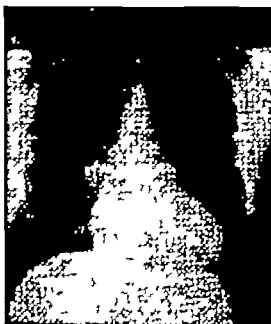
Posteroanterior roentgenogram. A 29 year old white male with ventricular septal defect. Note the increased pulmonary vascular markings. The pulmonary conus seems less prominent than is usual in these cases.
